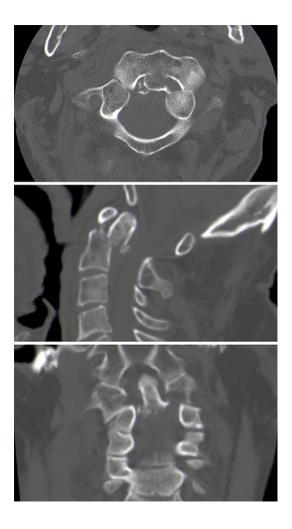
CT scan on admission to the Emergency Department.
